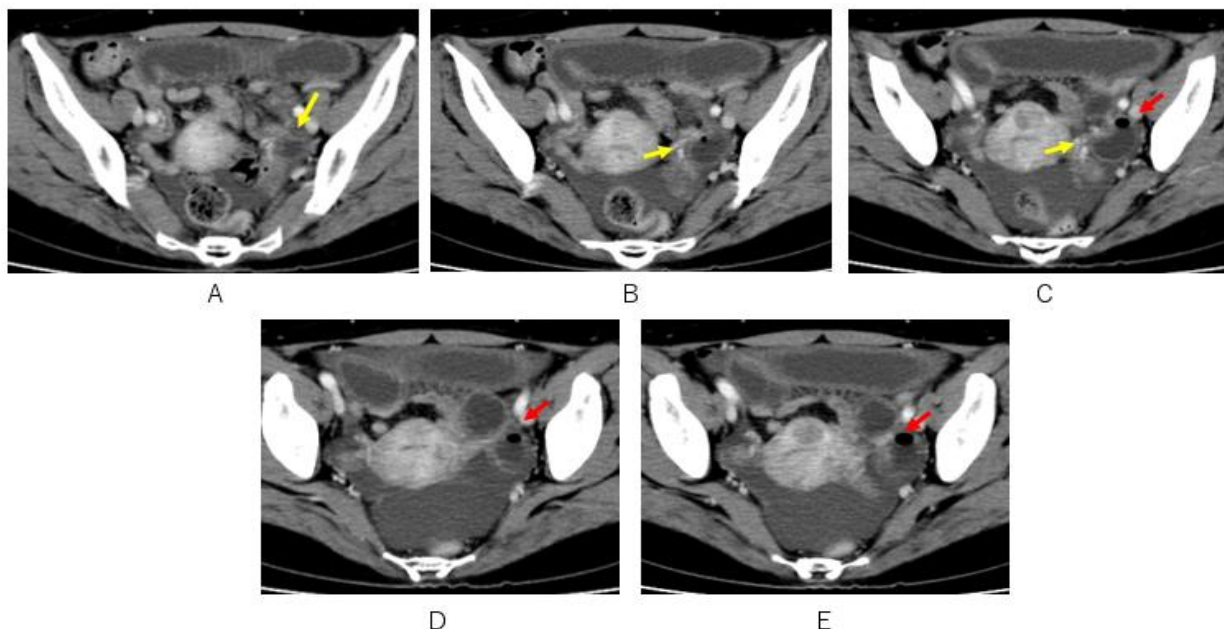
A localized Magatama (sea cucumber)-shaped dilated small bowel at the left side of uterus is depicted on contrast-enhanced CT(A-C). Left edge of the dilated small intestine indicates the transition knot between the dilated closed loop and the dilated oral-sided small intestine (C, D, E red arrow), while right edge of the dilated small bowel indicates another transition knot between the dilated closed loop and anal-sided constrictive small bowel (A-C, yellow arrow).
